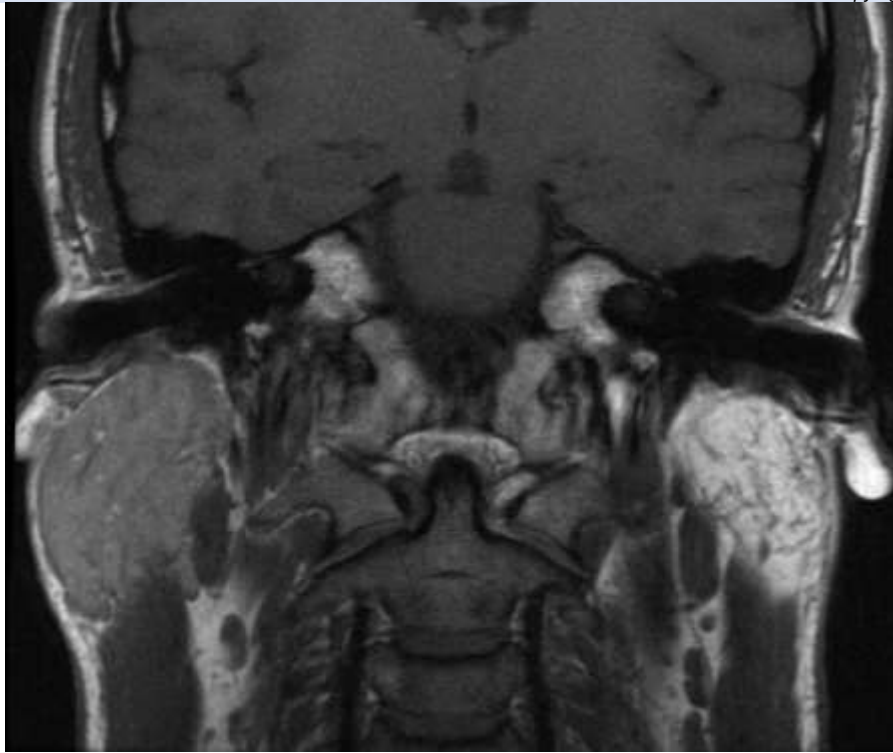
MRI coronal slice demonstrating normal right parotid gland and missing left gland
